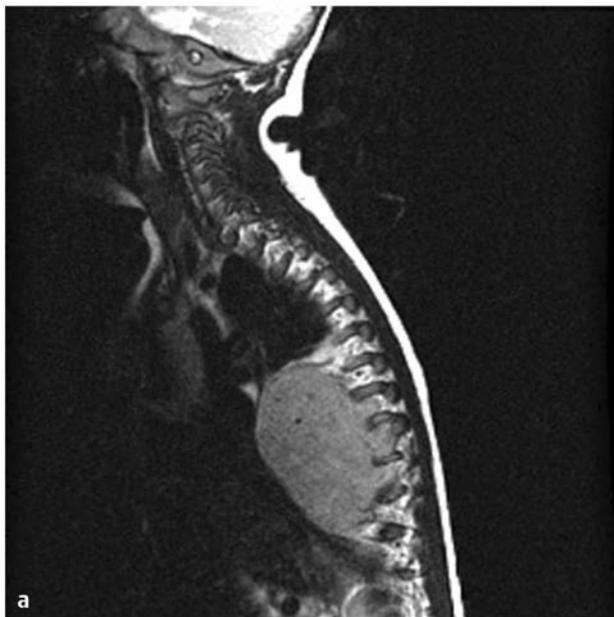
A 5-month-old boy presented with chronic cough. (a) Magnetic resonance imaging demonstrates a large neuroblastoma with extraspinal and intraspinal components. (b) On T1-weighted axial image, the intraspinal component is extradural and compresses the spinal cord laterally to the left.
